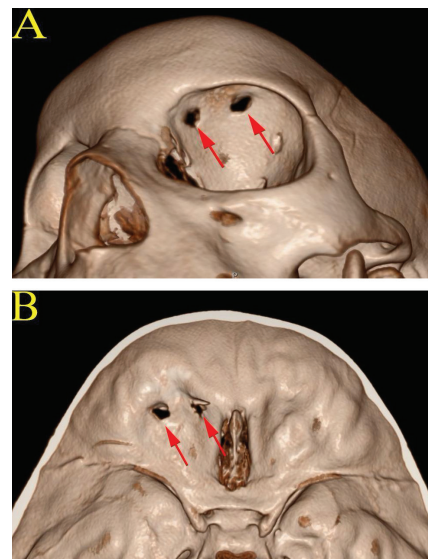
Three-dimensional reconstruction of the cranial computed tomography scan. The defect is visible from the exterior (A) and interior (B) aspects, marked by the red arrows
